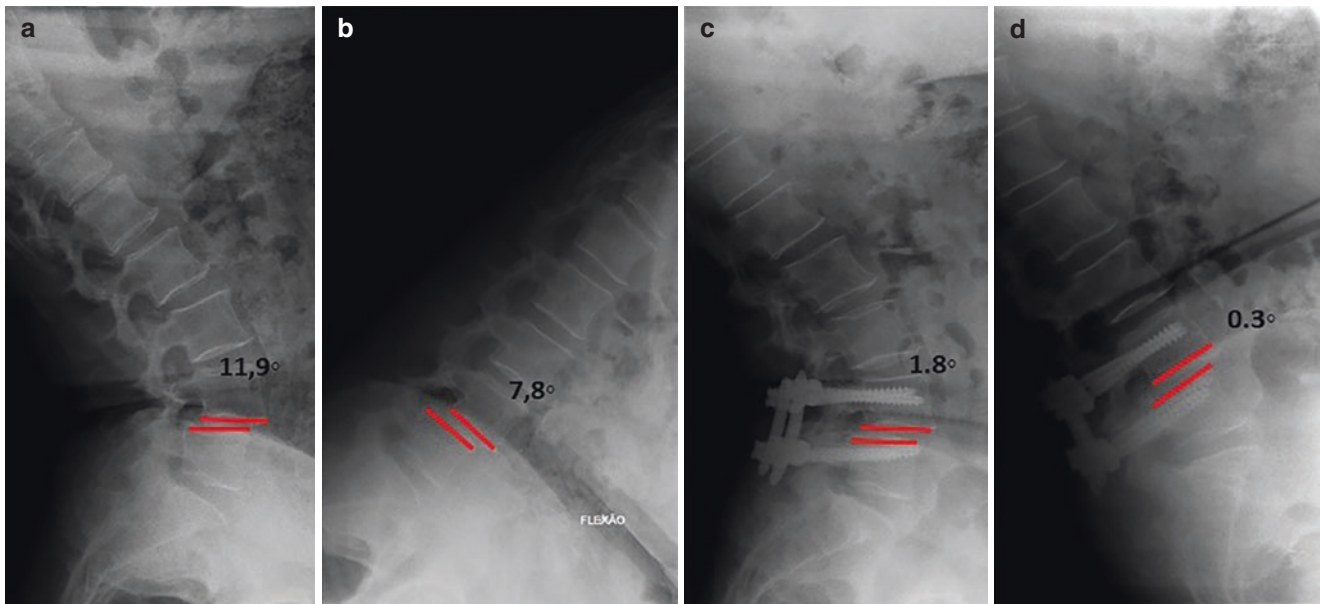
Preoperative (a, b) and postoperative (c, d) standing lumbar spine radiographs on lateral view demonstrating at L4-5 a postoperative decrease in ROM from 4.1° to 1.5°
